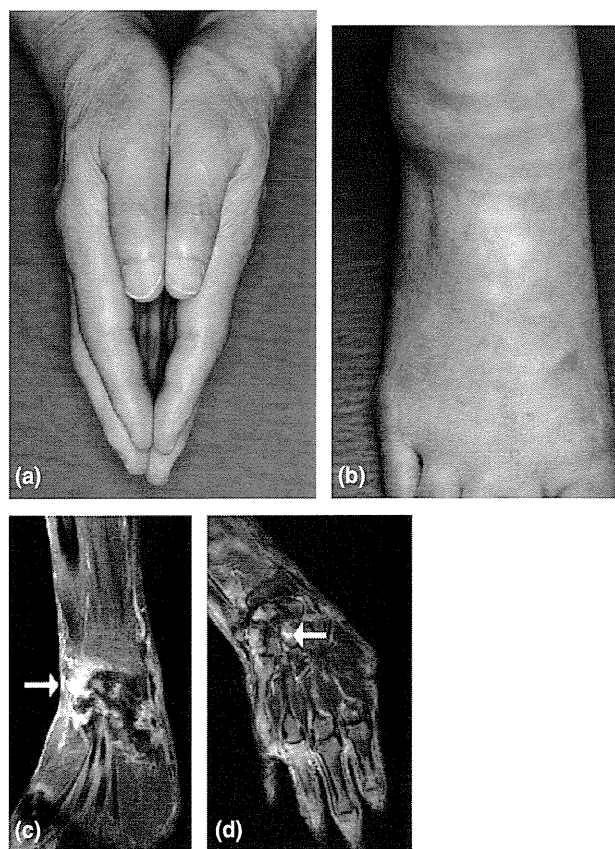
Clinical features of the patient before treatment. (a) The fingers and hands are red and swollen. (b) Pitting oedema is observed in the foot. (c, d) Enhanced MRI on the right hand shows synovitis (c: fat-suppressed images with gadolinium contrast agent) and bone oedema (d: high signal intensity on short tau inversion recovery).
